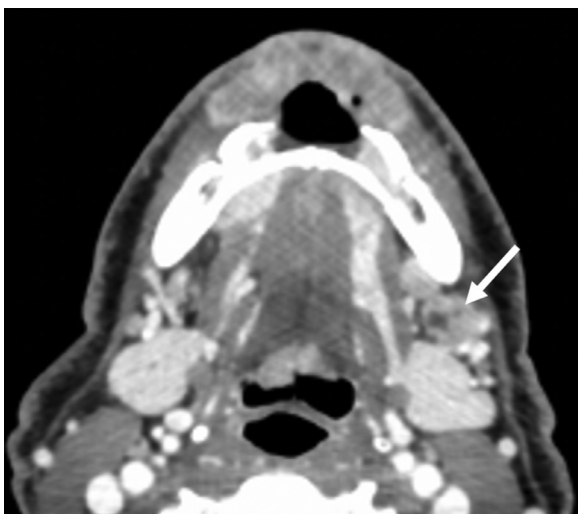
Axial contrast-enhanced computed tomographic image showing inhomogeneous enhancement of a large, destructive soft-tissue mass arising in the anterior mandible. There is a metastatic left level IB node that appears to have a necrotic center (arrow).
